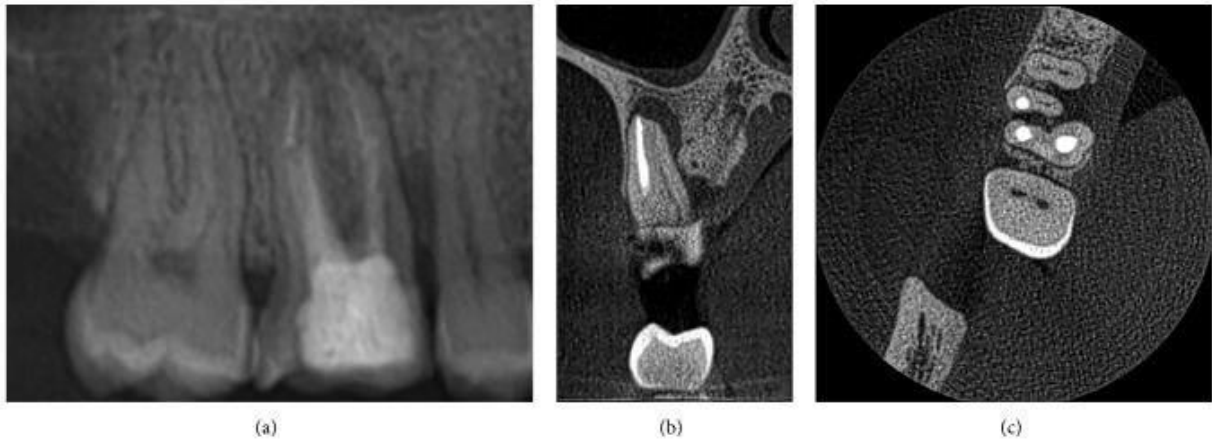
(a) Periapical X-ray: apex endodontic treatment and periapical radiolucency. (b) CBCT sagittal section: apex endodontic treatment MB, untreated MB2, and periapical radiolucency. (c) CBCT transversal section: untreated MB2. (Giudice *et al.*, 2018).
